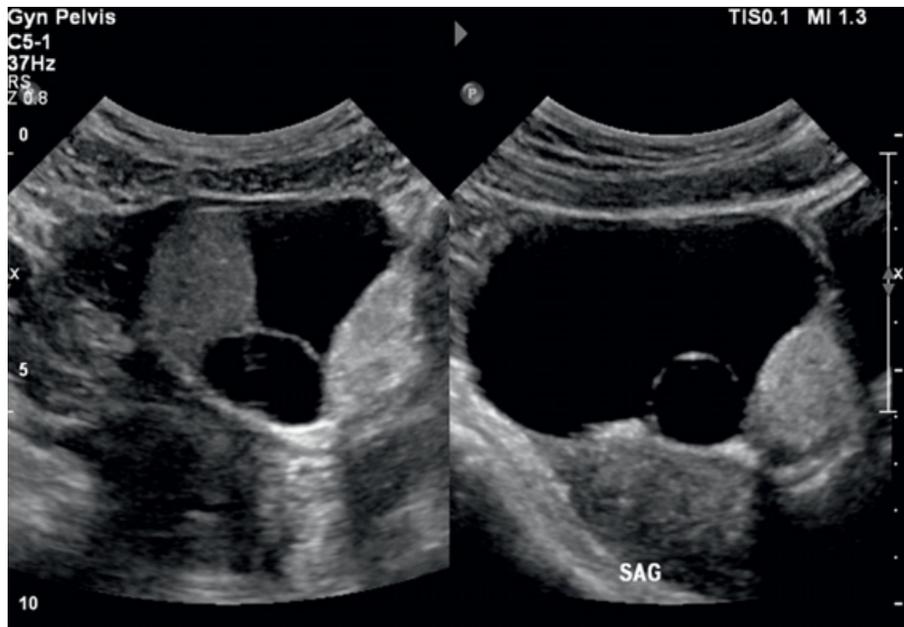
Typical ultrasound appearance of a dermoid tumor.
